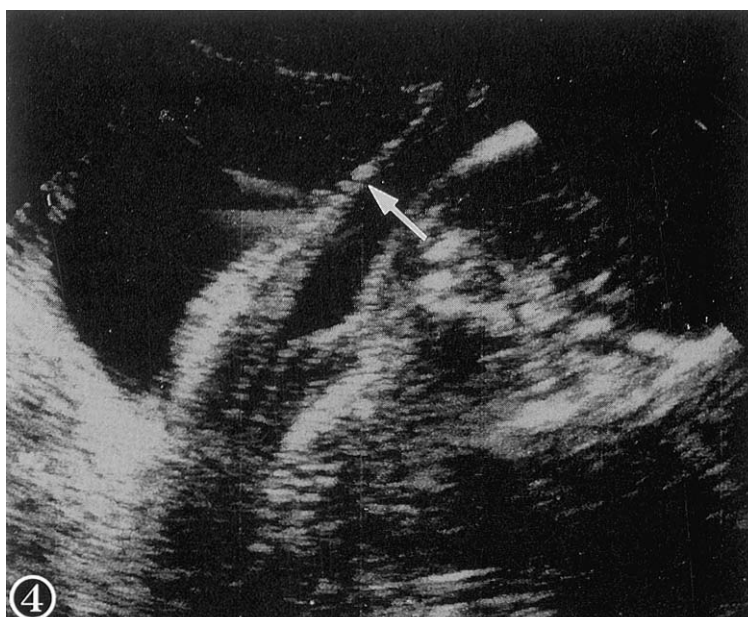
Sonogram of a patient at 22 weeks with a history of previous silent rupture of uterus. Myometrium shows loss of continuity (arrow).
